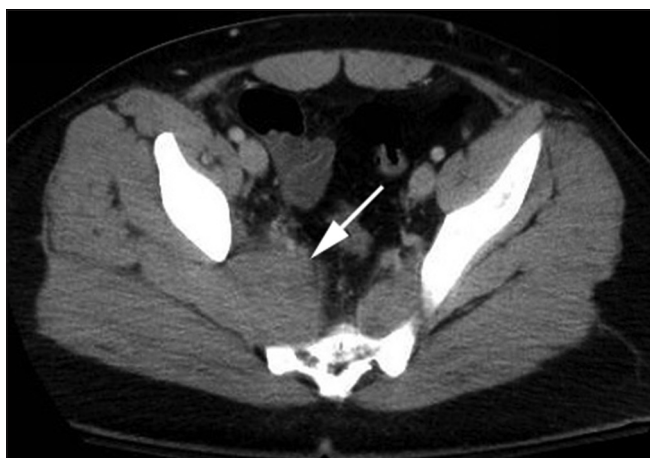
Computed tomography abdomen/pelvis with intravenous contrast showing a 5.2 × 4.2 cm amorphous, heterogeneously isodense lesion involving the right piriformis muscle at the level of the right greater sciatic foramen (arrow)
